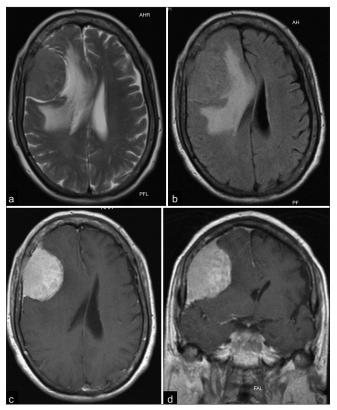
Preoperative magnetic resonance imaging. (a and b) Both T2-weighted imaging and T2 fluid-attenuated inversion recovery (FLAIR) images demonstrate a remarkable mass effect on the surrounding brain and vasogenic edema. (c and d) Axial T1weighted and coronal T1-weighted images showing a right frontal extra-axial lesion with homogeneous and avid enhancement.
